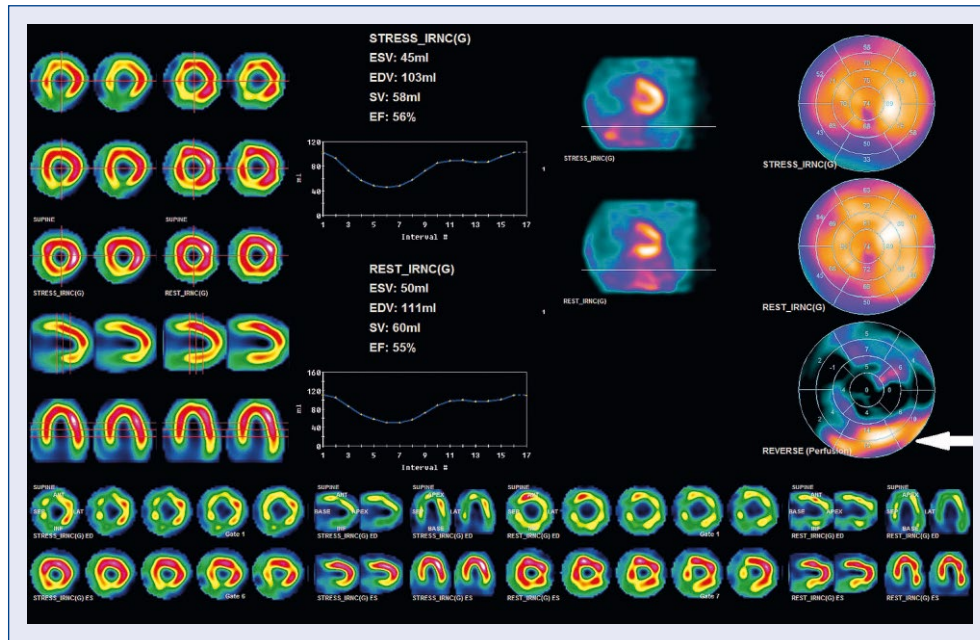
Single-photon emission computed tomography polar map display with reversible perfusion defect in basal and mid segments of inferior and posterior left ventricular wall (pointed with an arrow).
